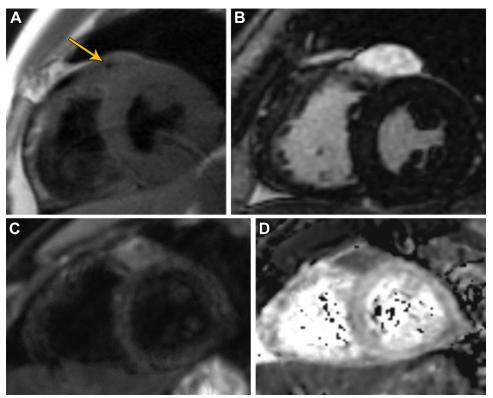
Lymphoma encasing the LAD in a 41-year-old man who presented with dyspnea at rest and on exertion. (A) Short-axis double inversion-recovery MR image shows a mass encasing the proximal LAD with intermediate T1-weighted signal intensity. Note the preserved LAD flow void (arrow). There was similar intermediate T2-weighted signal intensity at triple inversion imaging (not shown). (B) Delayed gadolinium-enhanced MR image shows the mass with intense homogeneous enhancement at delayed gadolinium imaging. (C, D) Short-axis diffusion-weighted (b value = 100 sec/mm²) (C) and apparent diffusion coefficient (D) MR images show characteristic restricted diffusion. The imaging characteristics strongly suggest lymphoma, which was confirmed at biopsy.
